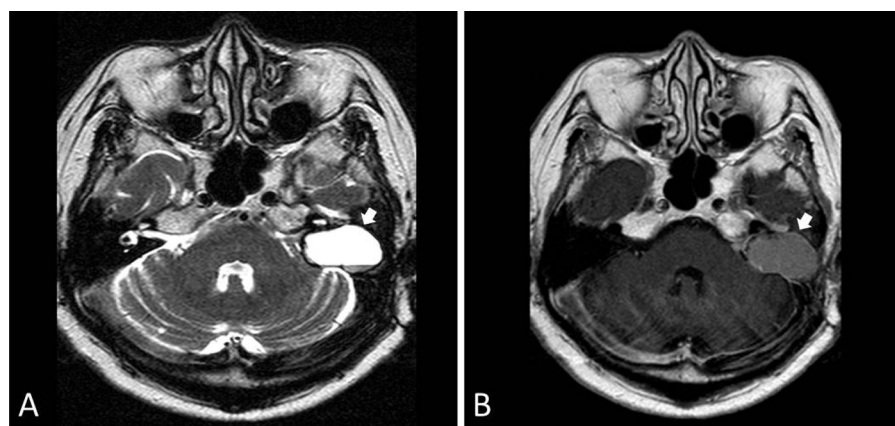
Magnetic resonance image (MRI) findings. T2-weighted image (A) and gadolinium-enhanced T1-weighted image (B). Contents of the epidural cyst in the left mastoid (arrows) showed slightly high intensity in T1-weighted images and obvious high intensity in T2 images. The cyst capsule was slightly enhanced by gadolinium.
